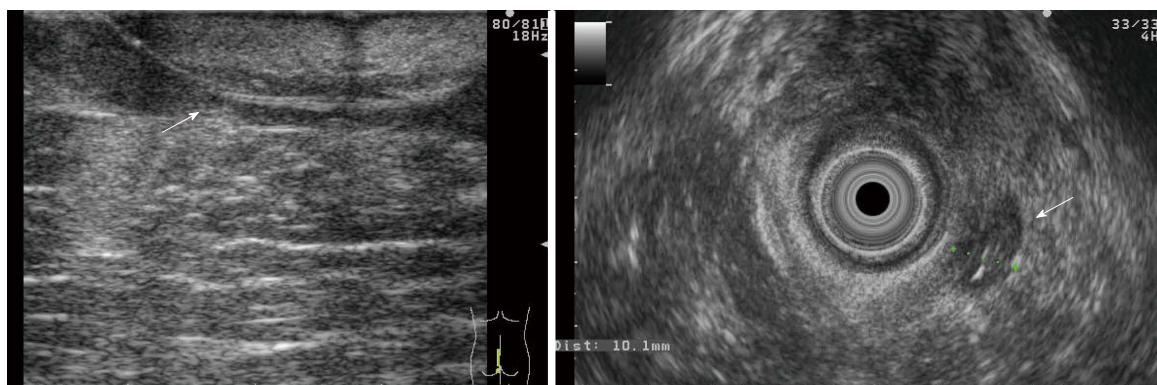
Transperineal and rectal ultrasound images of a patient with complicated perianal Crohn's disease: wide, hypoechoic fistula with seton thread.
